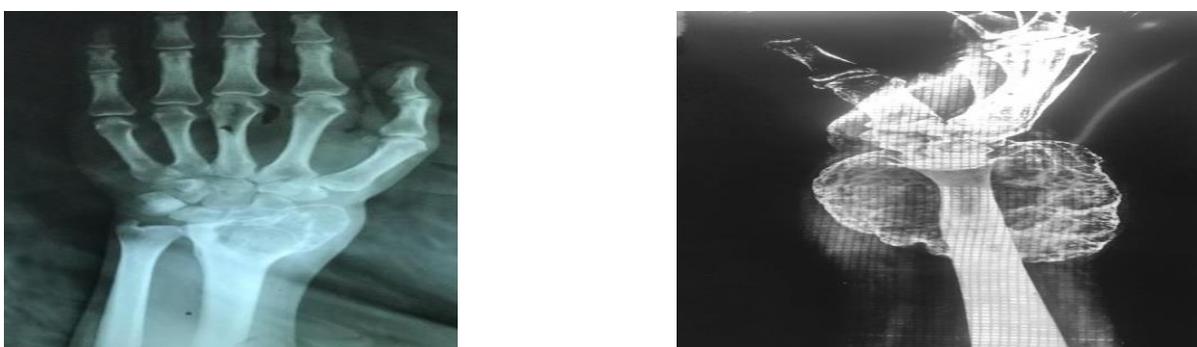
Xray Right Wrist Antero posterior and Lateral View: Showing Distal Radius Osteolytic Lesion with vollar and dorsal extension
